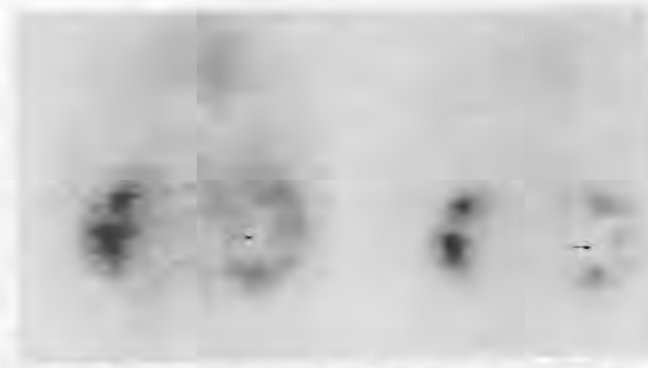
Two posterior images of the kidneys from a [99m Tc]-diethylenetriaminepentaacetic acid isotope renal scan. The right kidney demonstrates a large central photopenic zone (*arrow*) corresponding to the pyonephrosis and abscess shown by sonography. The left kidney is normal.
